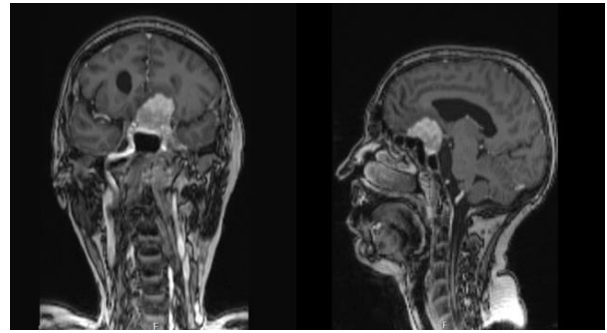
Pre-operative magnetic resonance image (MRI), T1-weighted MRI with gadolinium (Gd) enhancement, sagittal and coronal projection.
